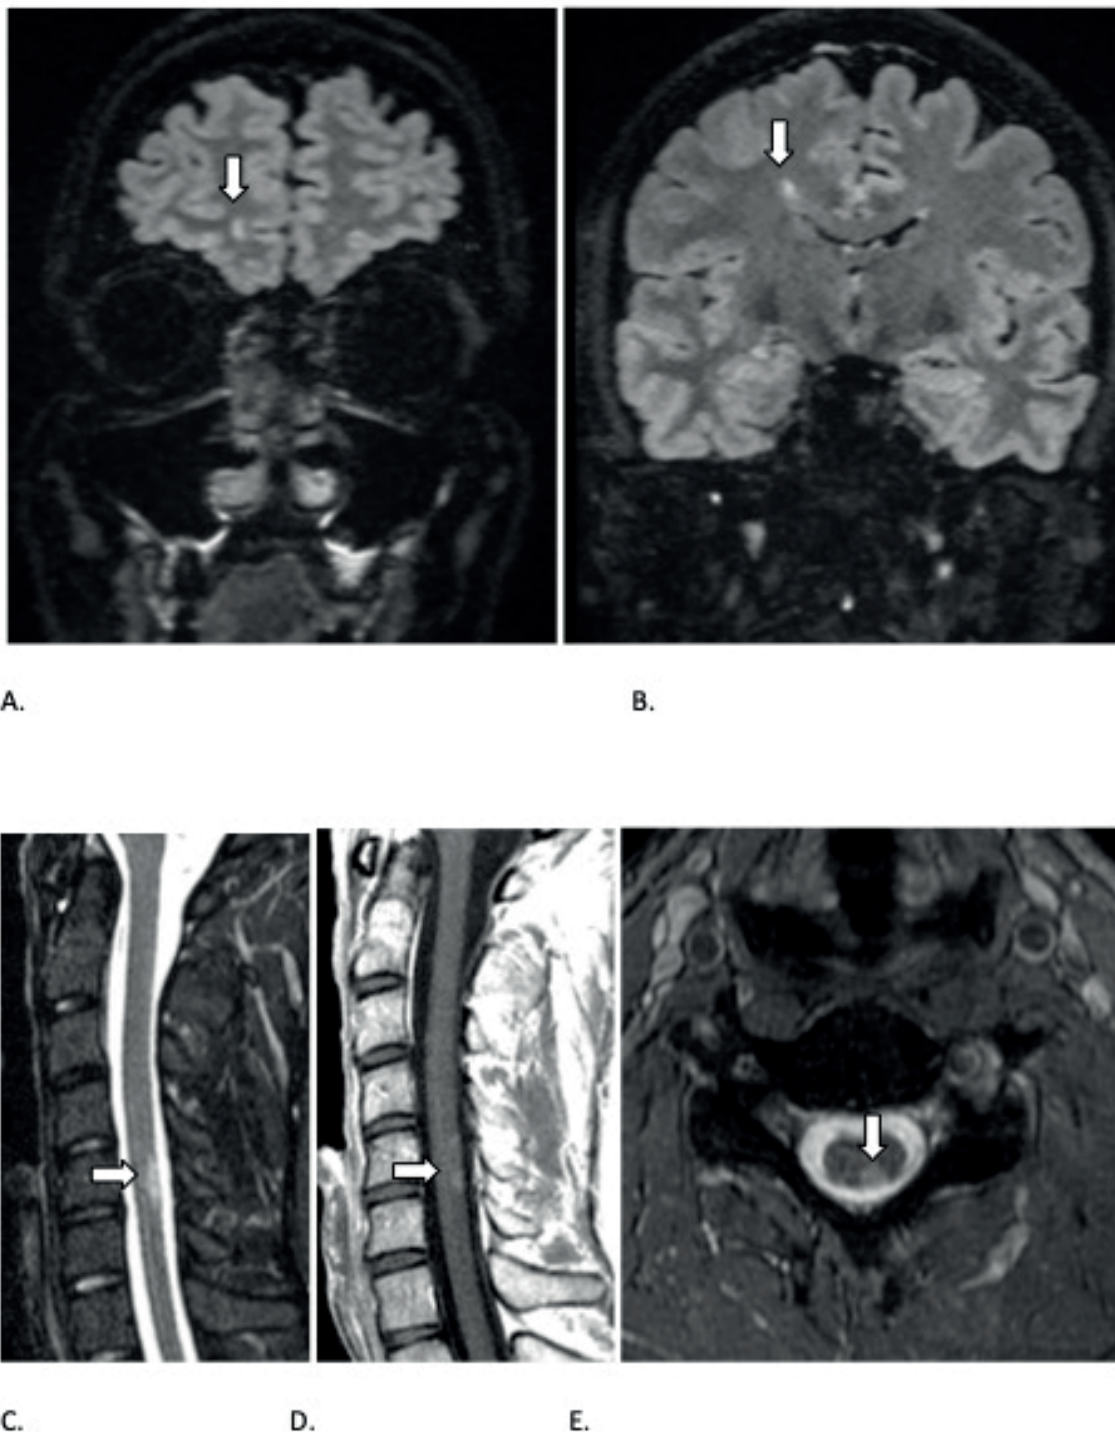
MRI of the brain and the spinal cord, T2 FLAIR 3D, STIR sag., T1 sag+C, T2 ax. A typical juxtacortical lesion in the right frontal lobe (A), a typical periventricular lesion (B), and a segmental gadolinium-enhanced lesion in the cervical part of the spinal cord (C, D, and E) that is compatible with demyelinating disease.
